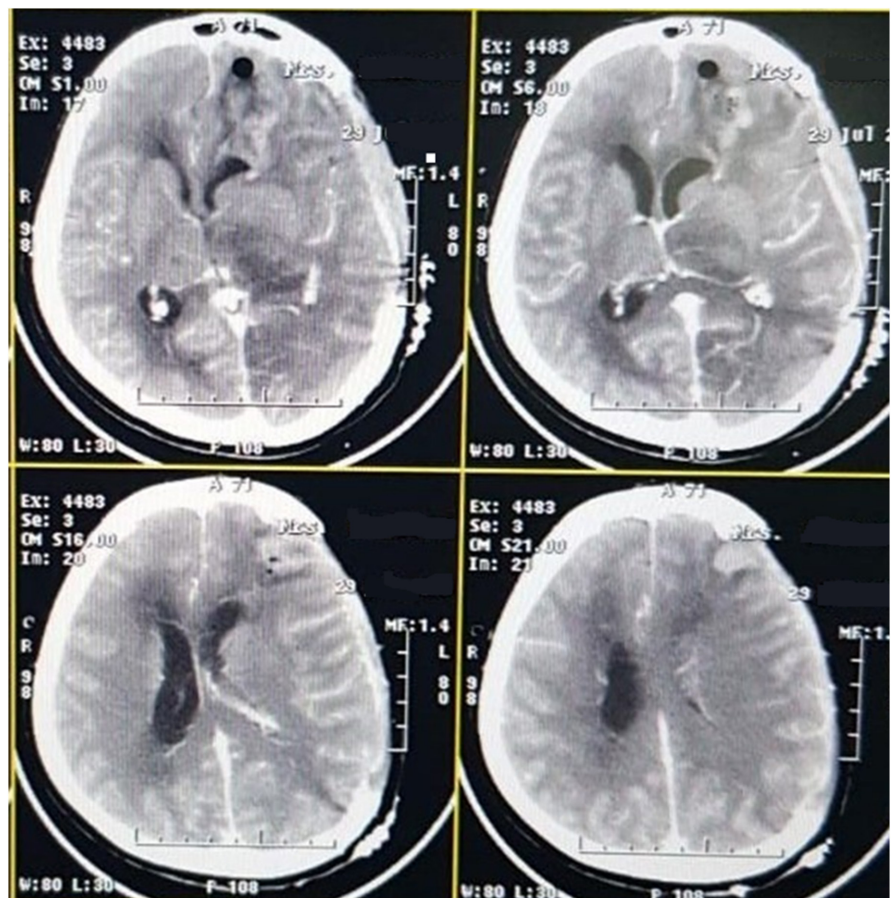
Postoperative brain CT scan showing the successful removal of the tumor.
